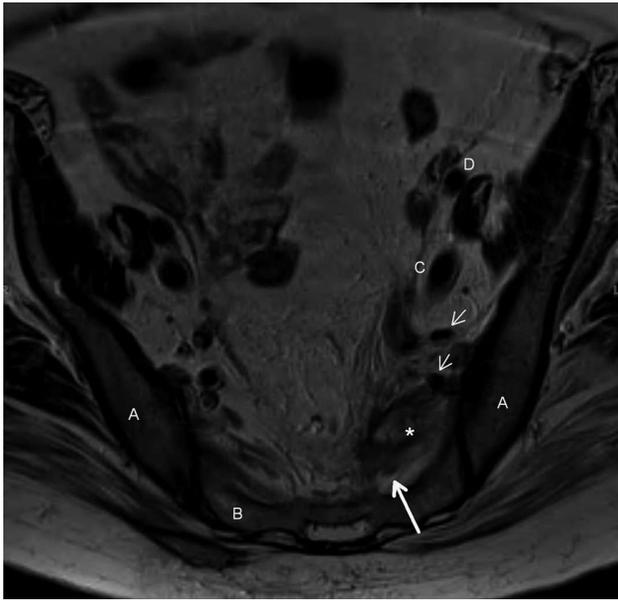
Axial T2-weighted image of pelvic MRI shows an exiting sacral nerve root (large arrow) about to be encased by the mass. \* = mass; A = iliac bone; B = sacrum; C = external iliac vein; D = external iliac artery; small arrows = branches of internal iliac artery; large arrow = exiting sacral nerve about to be encased by mass.
